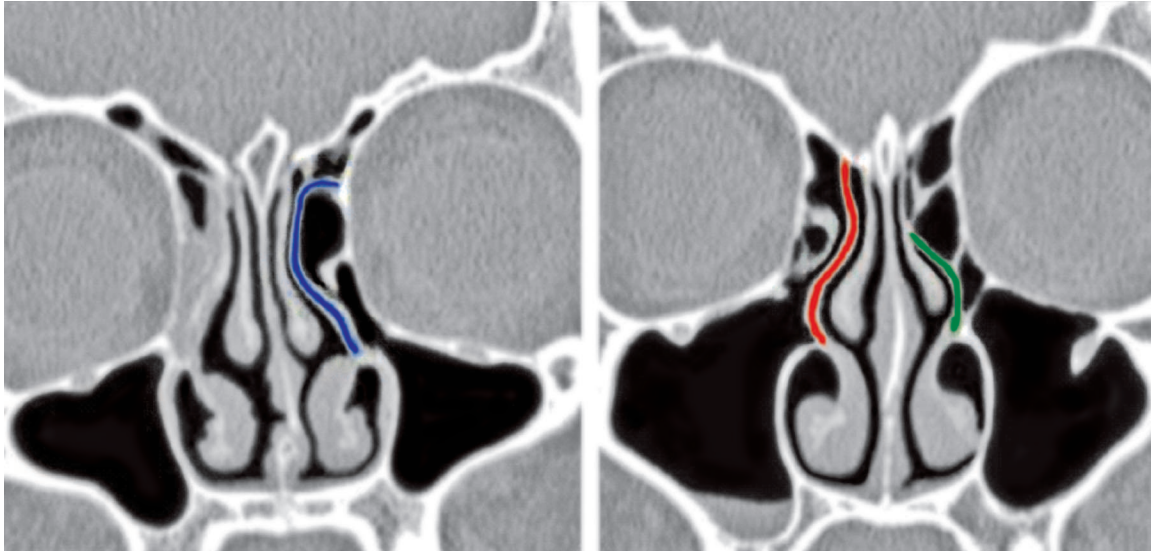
CT scans showing different types of uncinate process: Type-1 (•), Type-2 (•), Type-3 (•)
